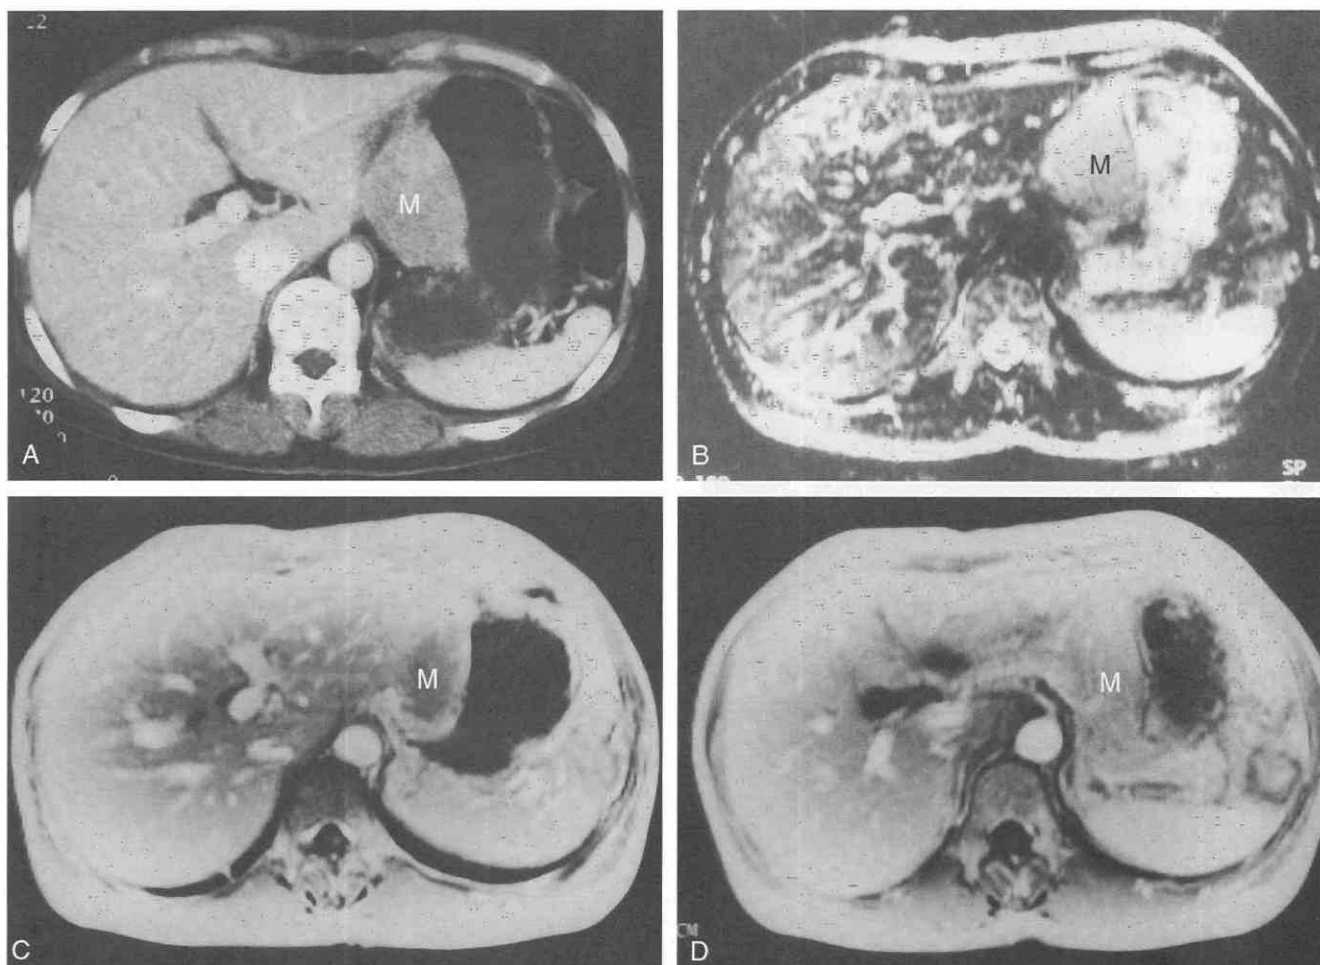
Gastric lymphoma. A, A mass (M) is seen in the gastric wall along the lesser curvature of the stomach on CT scan. B, T2-weighted MR image shows a mass (M) with intermediate signal intensity. C and D, Dynamic gadolinium-enhanced MR images show poor contrast enhancement of the mass (M) in the early phase (C) and isointensity to that of the liver in the delayed phase (D).
